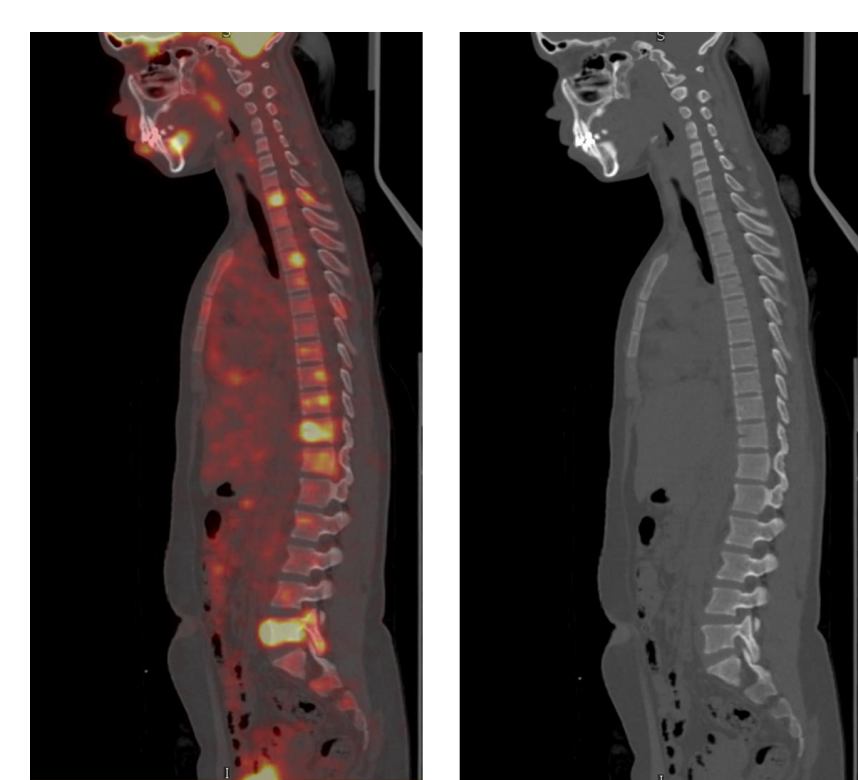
Metabolically active lesions identified in the marrow, not seen on CT, resulting in upgrade of initial stage
